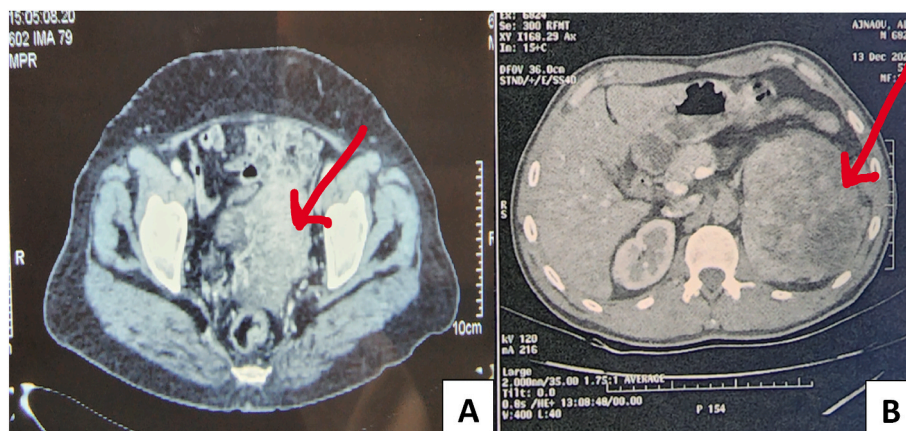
CT scan demonstrating the presence of a rectosigmoid mass (A) and solid renal mass (B).
